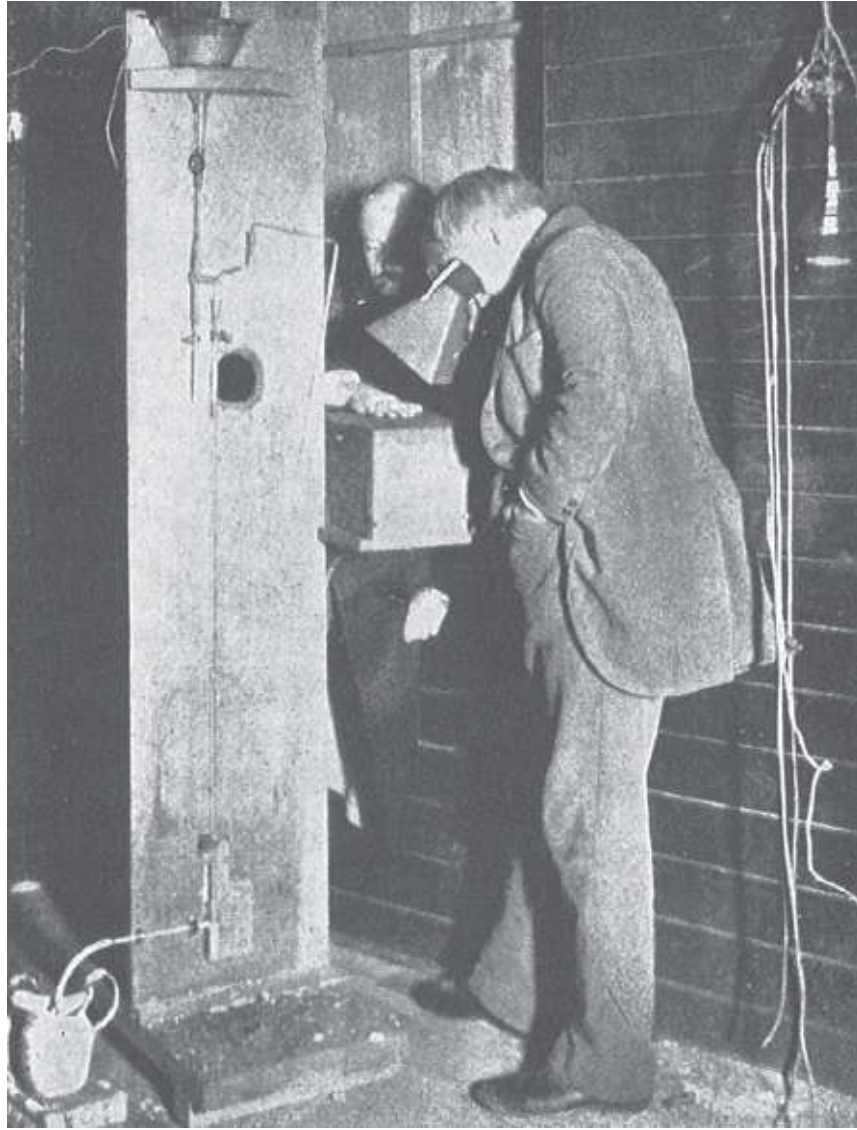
Thomas A. Edison experimenting with x-rays with, obviously, no radiation protection. (From Glasser O. *Dr. W.C. Röntgen*. Springfield: Charles C. Thomas, 1945, with permission.)
